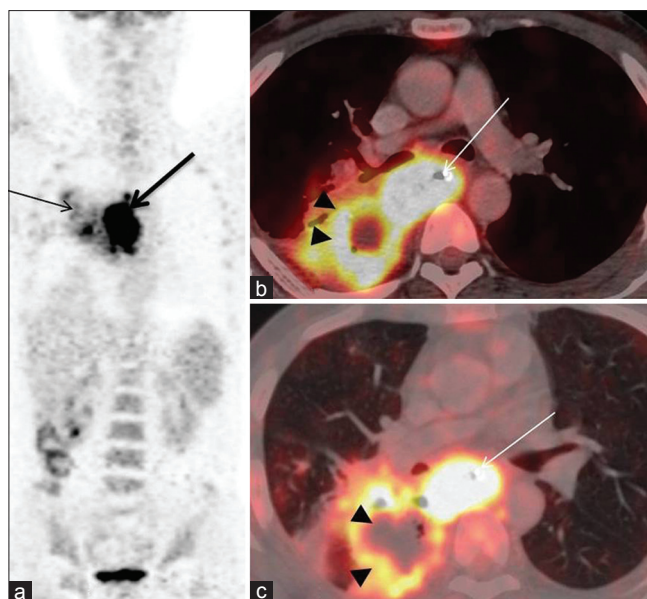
(a) MIP image showing intense FDG uptake in mid-thorax (thick arrow) with an area of low grade uptake abutting it (thin arrow), (b and c) Axial PET/CT images show large middle esophageal mass with bronchial invasion (arrow) with a centrally necrotic ill-defined mass adjacent to it (arrow heads)
